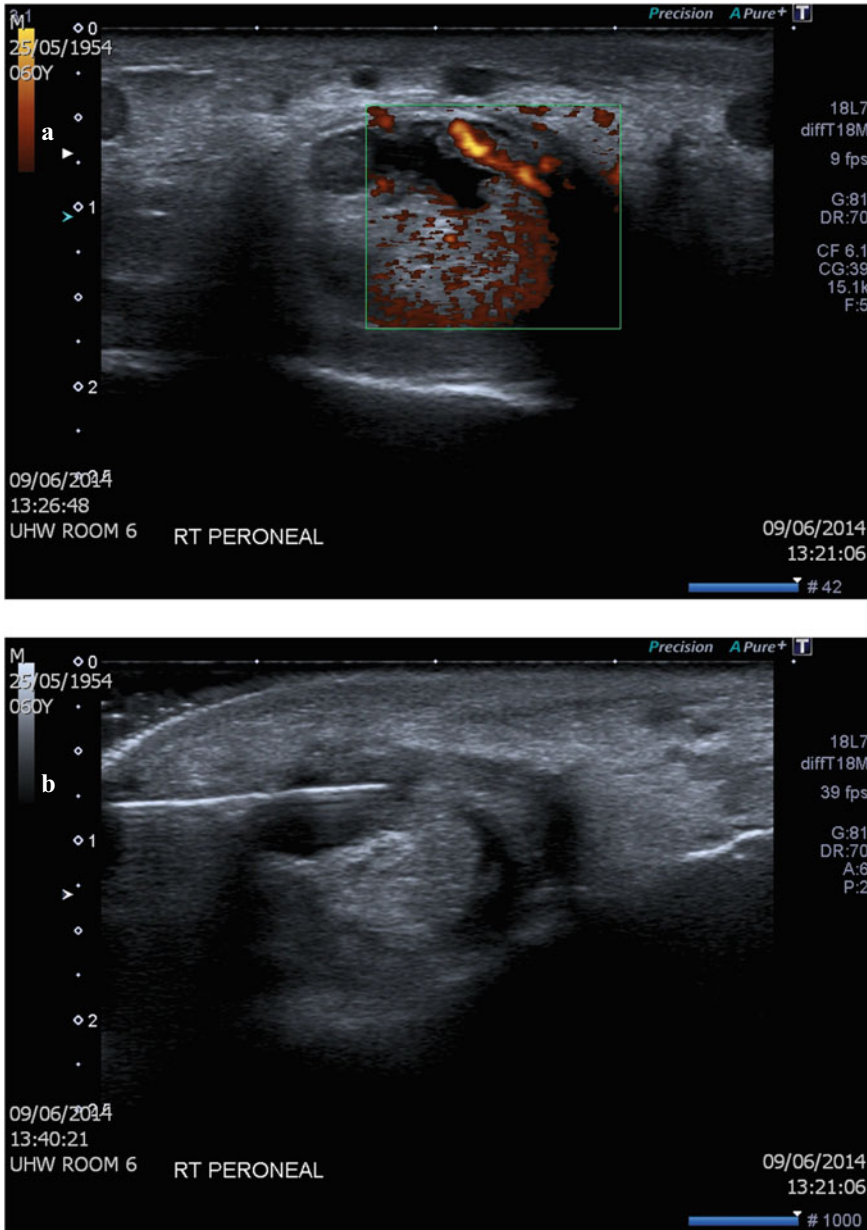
a Identification of collection surrounding the right peroneal tendon with doppler indicating localised increased vascularity. b Aspiration of infected collection surrounding the right peroneal tendon
